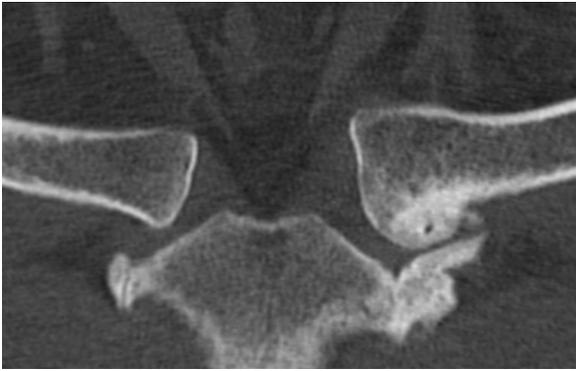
Computed tomography scan demonstrating arthritic costoclavicular joint.
